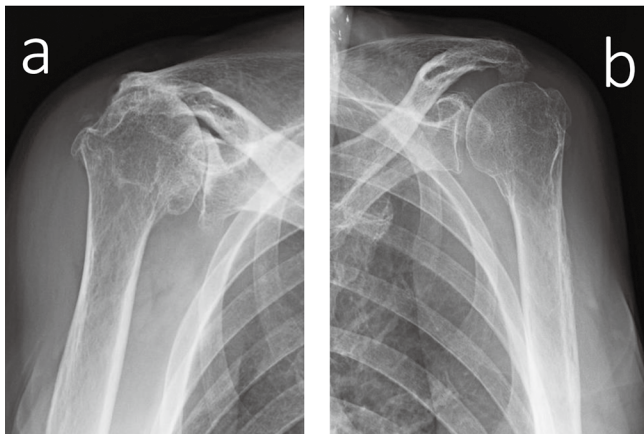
A preoperative plain X-ray of case 2.
